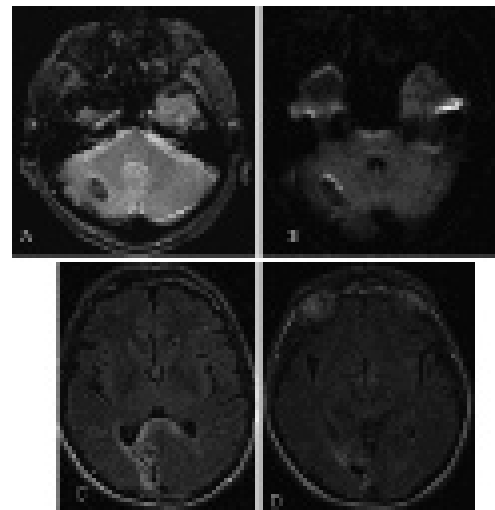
This MRI was obtained one day after embolization. A: Gradient echo MRI. B: Diffusion-weighted MRI. A small hemorrhagic lesion of the right cerebellar hemisphere is depicted. C and D: FLAIR MRI shows the unchanged right occipital stroke.
